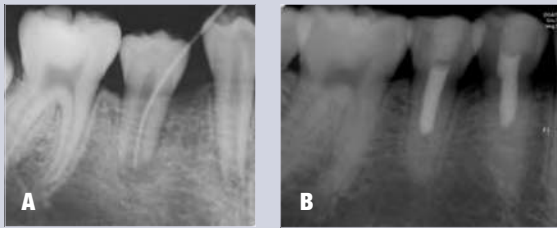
(A) Preoperative radiograph of tooth #29. (B) Five-year follow-up after regenerative endodontic treatment. Reprinted with permission from Jung IY, Lee SJ, Hargreaves KM. Biologically based treatment of immature permanent teeth with pulpal necrosis: a case series. J Endod 2008;34:876–87.
